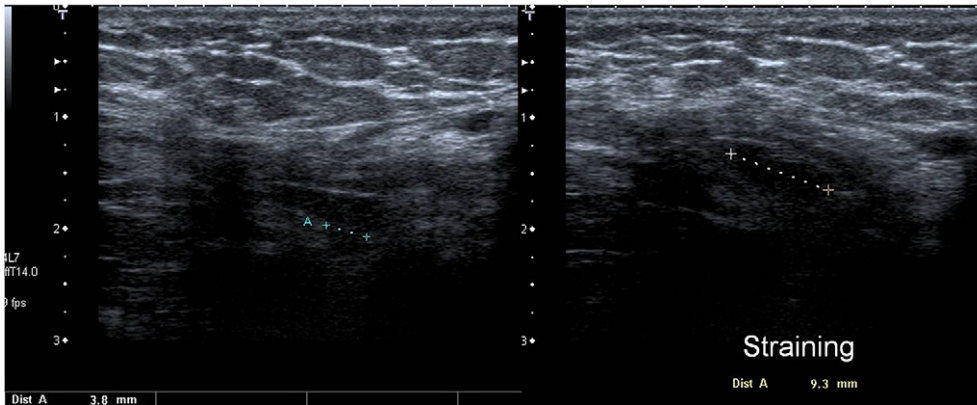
Real-time imaging is an advantage of ultrasound. Note how the defect in abdominal wall gets bigger on straining in this patient with a hernia.
